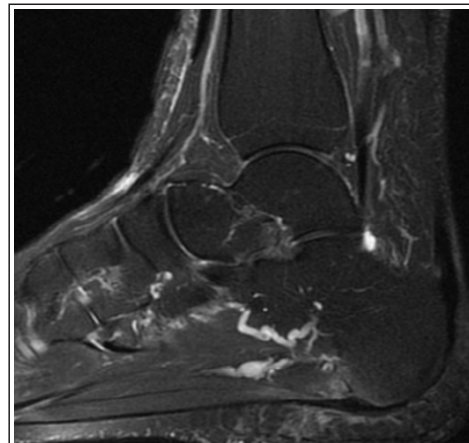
The thickness of the plantar fascia (PF), findings of a high-signal intensity area inside the PF, edema around the PF, and bone marrow edema of the calcaneus are MRI typical findings of PF.6.
